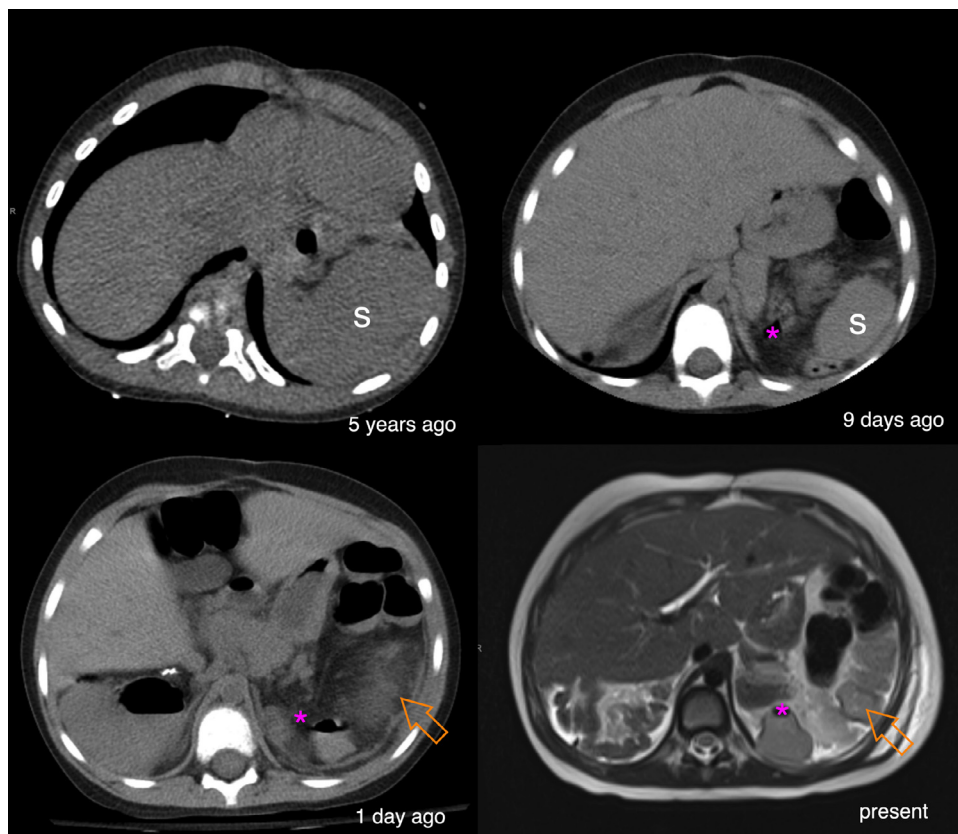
Axial CT through the abdomen without contrast (A-C) and axial T2 weighted MRI of the abdomen (D) at different time-points. The spleen (s) is in the expected anatomic location in the left upper quadrant but in slightly different locations 9 days and 5 years prior (A,B). Imaging after the patient's initial laparoscopic surgery 1 day prior and present day (C,D) show an empty splenic fossa (orange arrows). Left kidney is absent from the left renal fossa (*).
